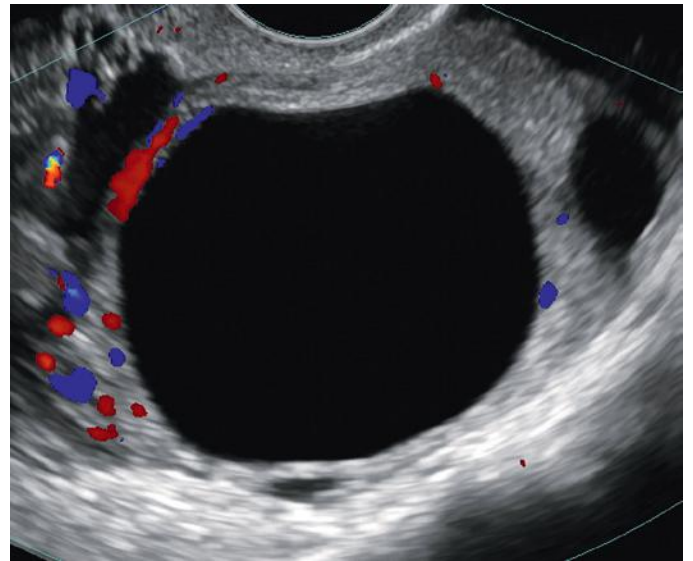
Simple ovarian cyst. Color Doppler ultrasound image of a simple ovarian cyst demonstrates the characteristic findings of anechoic contents, smooth thin wall, no internal vascularity, and posterior acoustic enhancement.
